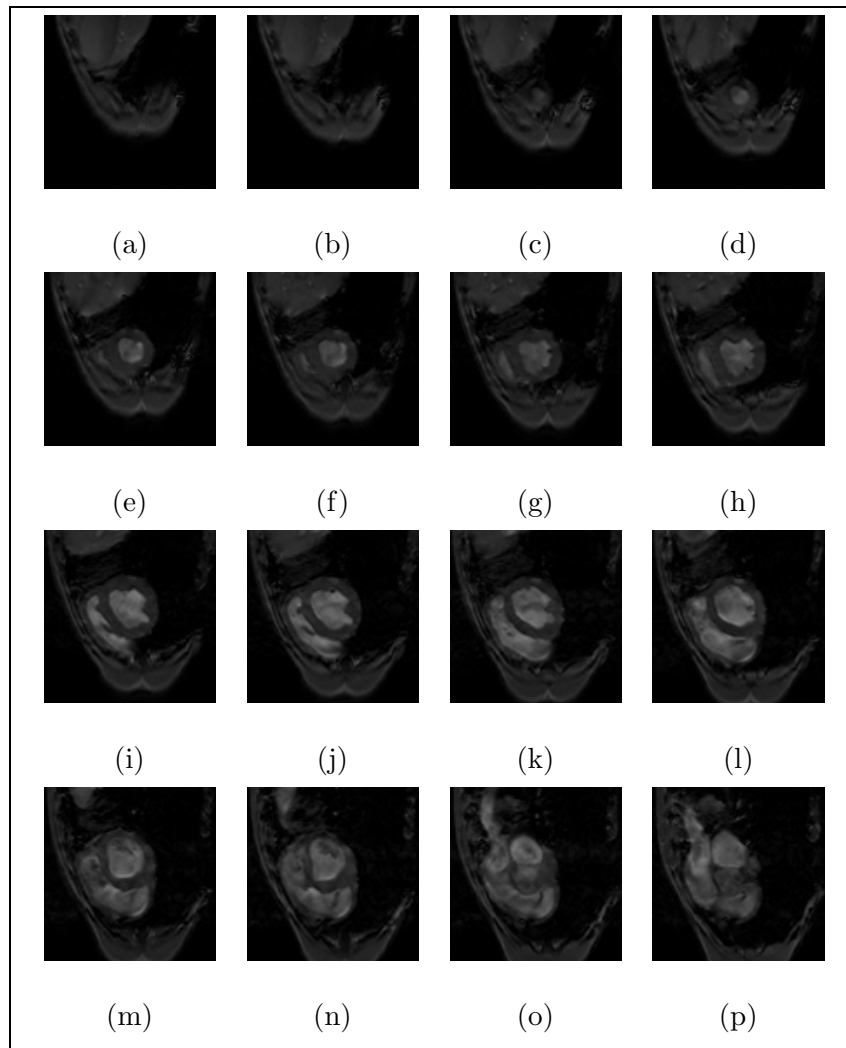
Sixteen spatial MRI images which cover the entire left ventricle. The images run from top to bottom, left to right to cover the LV from apex to base.
